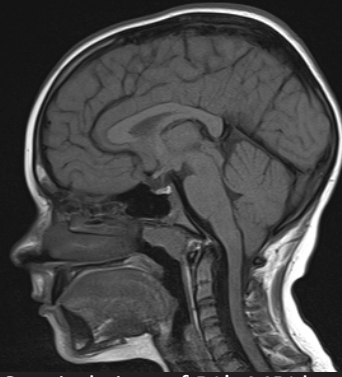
Saggital view of DL's MRI brain showing 13mm of tonsillar herniation.
